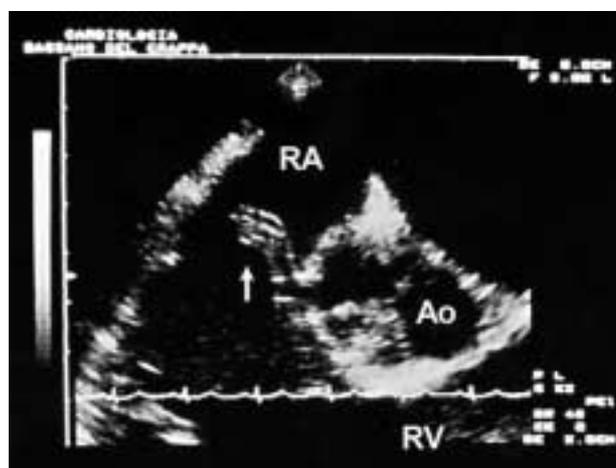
Longitudinal transesophageal view showing a discontinuity of the enlarged noncoronary sinus of Valsalva. Proximal to its edges, a fibrous structure with a "wind sock" appearance (arrow) may be seen. Ao = aorta. Other abbreviations as in figure 1.
